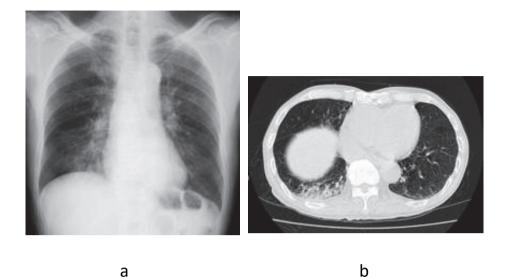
A 83-year-old man showed an infiltrative shadow in the right lower lung field on a chest radiograph (a) and a similar shadow in the right lower lobe with emphysematous change on chest CT (b). (Diagnosis: Lower lung field tuberculosis)
